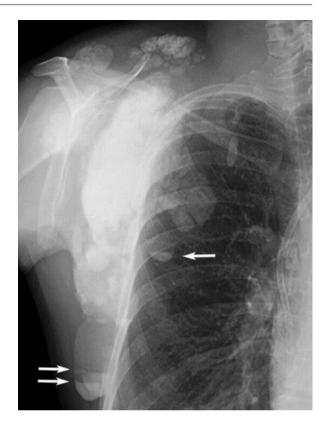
Tumoral calcinosis of the shoulder girdle. Antero-posterior radiograph shows multiple rounded calcified masses, some of which demonstrate sedimentation (arrows)
